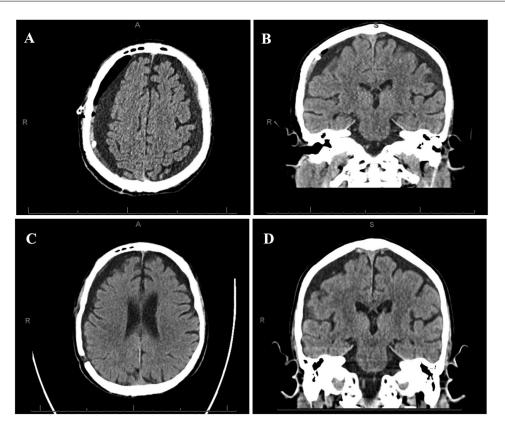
Head CT on postoperative (craniotomy) day one (A&B) and 4 months follow-up (C&D). Axial (A) and coronal (B) CT obtained on postcraniotomy and drain placement day one showed a decrease in size of right subdural hematoma to 1.9 cm (previously 3 cm) with resolution of midline shift (previously 1 cm). A repeat CT (C: axial, D: coronal) at 4 months follow-up showed a decreased 1.2 cm right sided subdural collection.
